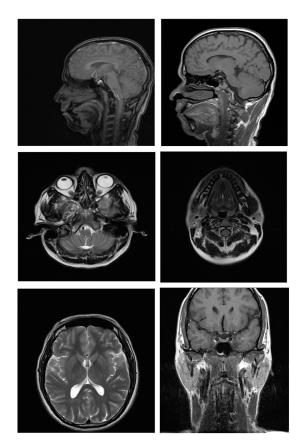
Magnetic resonance imaging (MRI) scans of the head and neck region with JJ Orthodontics Ora-plus polycarbonate brackets
